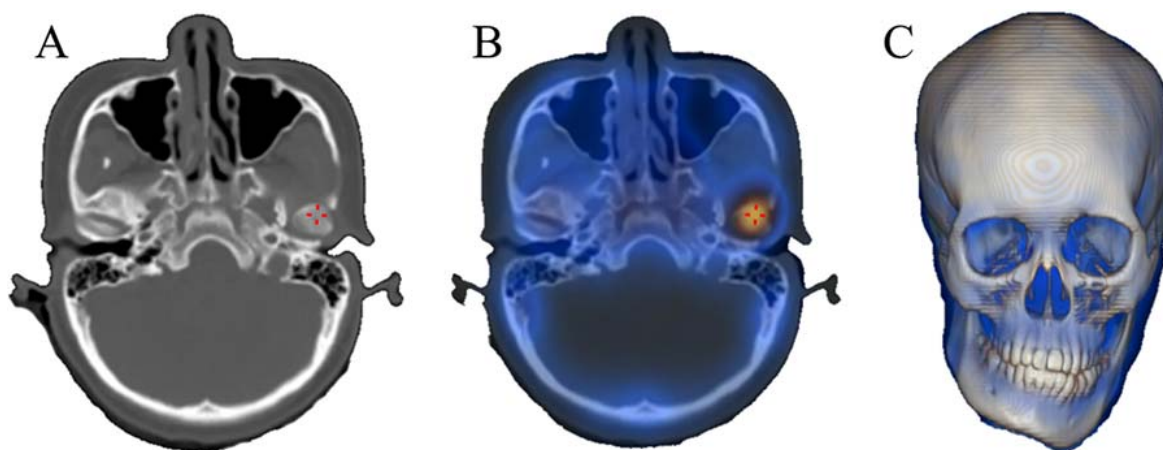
SPECT/CT of the skull from the same patient as in Fig. 1. Anatomical CT (A) at the level of the mandibular condyles shows enlargement of the left condyle. Fused SPECT/CT (B) shows intense radiopharmaceutical uptake in the left condyle. Three-dimensional CT volume render of the skull shows marked deviation of the chin to the right side. These findings indicate active hyperplasia of the left mandibular condyle.
